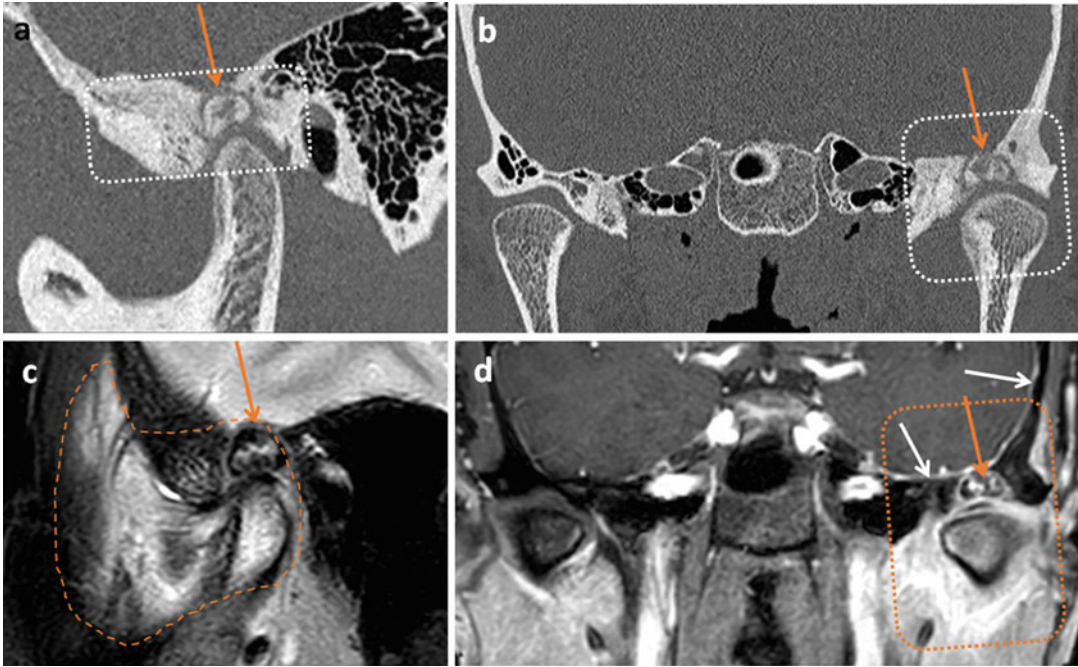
Osteoid osteoma of the left glenoid fossa and articular eminence; presentation with pain and trismus in a young adult patient. Sagittal bone window CT reconstruction (a), coronal bone window reconstruction (b), fat saturation T2 sagittal MRI of the left TMJ (c), and post-gadolinium, fat saturation T1 coronal MRI (d). There is a round sclerotic nidus representing an osteoid osteoma with a lucent margin measuring 10 mm in diameter in the roof of the glenoid fossa (orange arrows). There is diffuse sclerosis of the articular eminence, root of the zygoma, remainder of the glenoid fossa, and to a lesser extent the condyle (white dotted oval in a, white dotted square in b). Extensive, hyperintense marrow and soft
